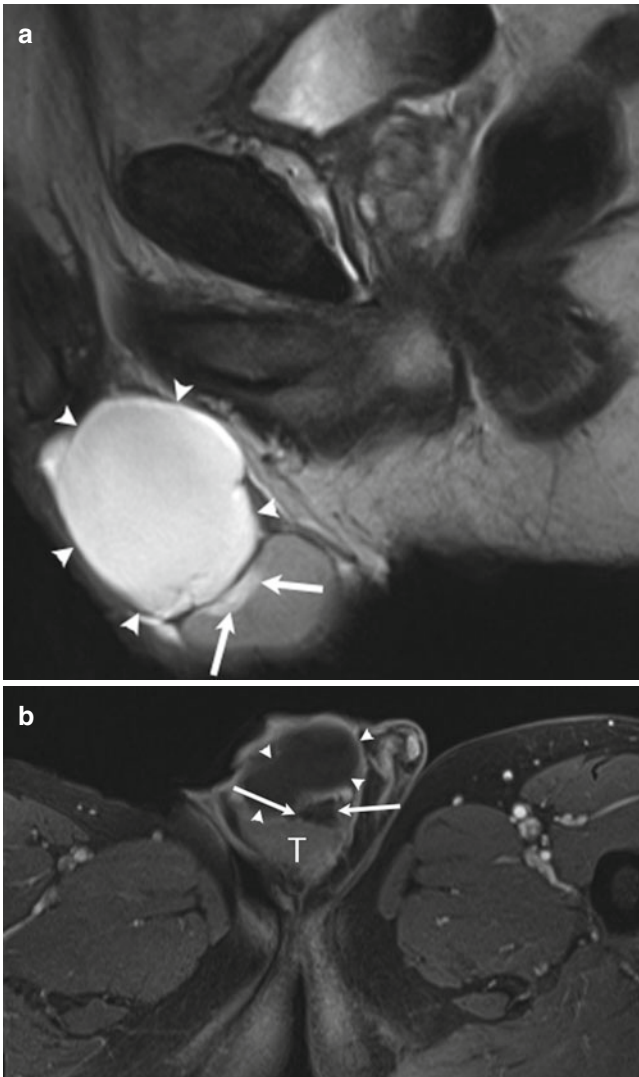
Epididymal head cyst and dilatation of the rete testes. Sagittal T2-weighted (a) and axial T1-weighted gadolinium-enhanced images (b) demonstrate a large mass (arrowheads) above the right testicle (“T” in (b)). This is uniformly hyperintense on the T2-weighted and does not enhance, compatible with an epididymal head cyst. The patient had been referred to MRI for the evaluation of an indeterminate testicular lesion seen on ultrasound. The lesion (arrows) is bright on the T2-weighted sequence and does not enhance, compatible with a benign lesion, most likely dilatation of the rete testes
